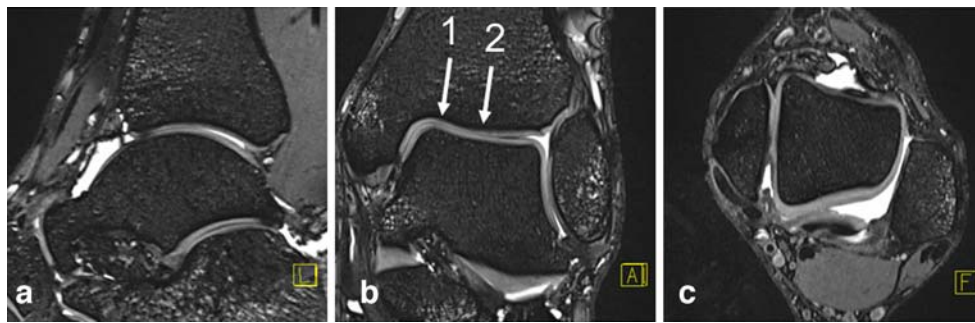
High-resolution morphological isotropic ($0.31 \times 0.31 \times 0.31$ mm) MRI using the 3D true fast imaging with steady-state precession (True-FISP) sequence. Reconstructed a sagittal, b coronal, and c axial view of the ankle of a healthy volunteer. Further sagittal measurements were
